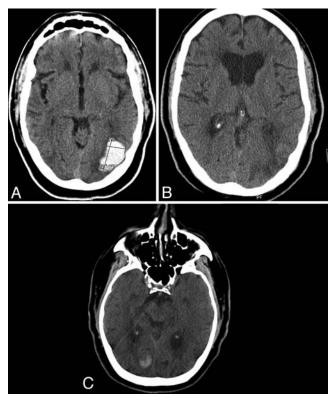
A: Non-contrast administered CT scan of the head showing the patient's first diagnosed CAA-associated ICH in the left parietooccipital lobe. B: Interval CT of the head without contrast demonstrating resolution of the previous CAA-associated ICH at a 6-month followup visit. C: Non-contrast administered CT scan of the head in the same patient several months later, demonstrating a new ICH in the right occipital lobe. This occurred in the region of previous gradient echo changes seen in Fig. 4A.
